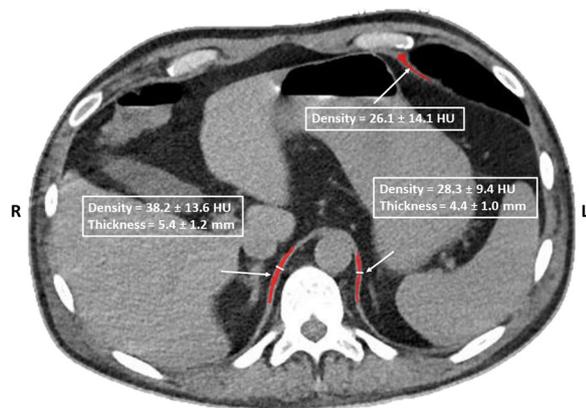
(abstract 000305) Example of CT slice with three regions of interest in red and two thickness measurements in the posterior part of the diaphragm. Values inside white boxes are mean values \pm standard deviation for the complete population. HU = Hounsfield Unit, Std = Standard deviation
